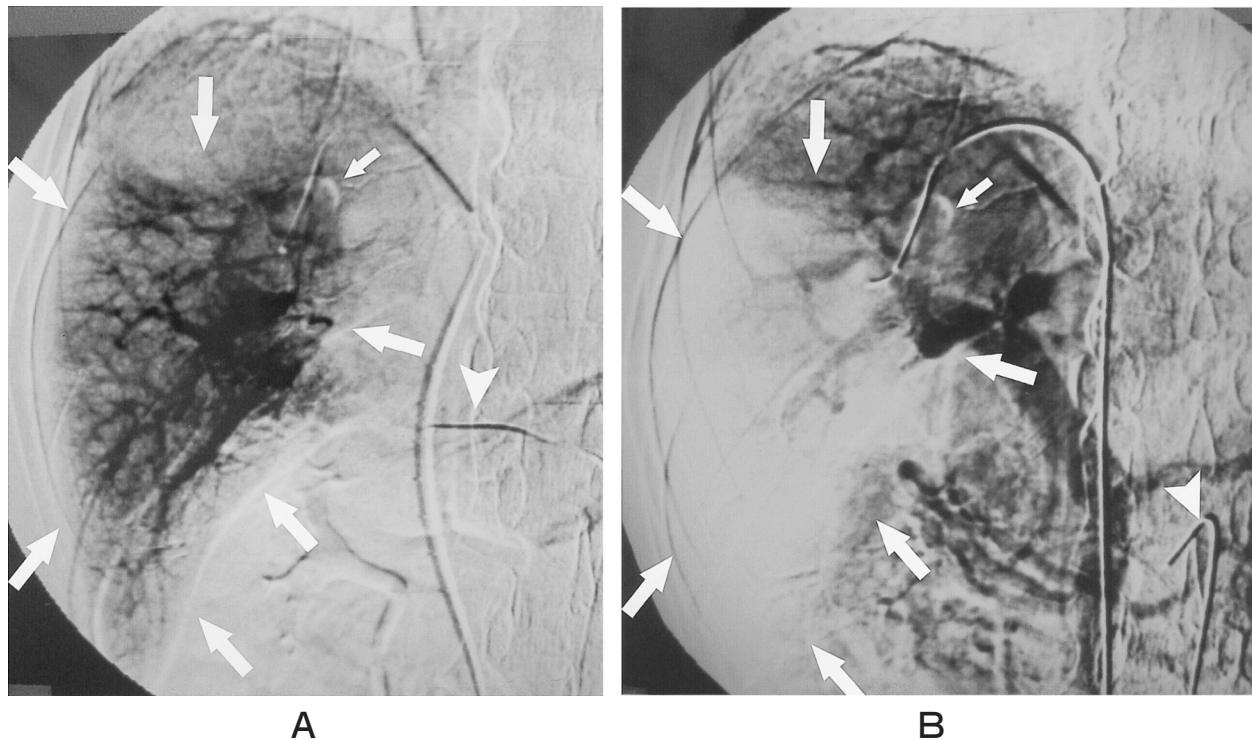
Hepatic arteriogram (A) and arterial portogram (B) under HVO. The occluded area (large arrows) indicates prolonged enhancement on hepatogram with hepatofugal portal opacification on the hepatic arteriogram and perfusion defect with less portal opacification on the arterial portogram. Small arrows demonstrate an inflated balloon in the RHV. Arrowhead indicates a catheter introduced into the common hepatic artery (A) or into the superior mesenteric artery (B). (Panels (A) and (B) are reprinted with permission from Hiraki T., *Altered Hemodynamics in the Liver Caused by Temporary Occlusion of the Hepatic Vein: Evaluation with Doppler Ultrasonography in 14 Patients*. *Radiology* (2001) 220: 357–364.)
